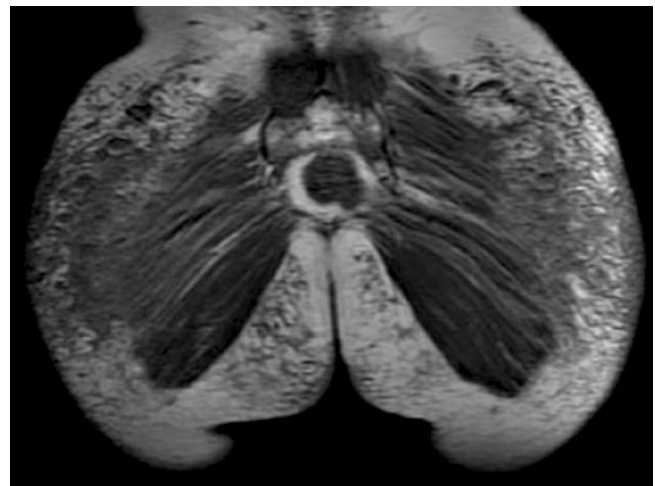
MRI of the gluteal region of a patient who had received injections of illegal silicone 5 years earlier, showing spreading of the liquid silicone to the subcutaneous and muscular layers
